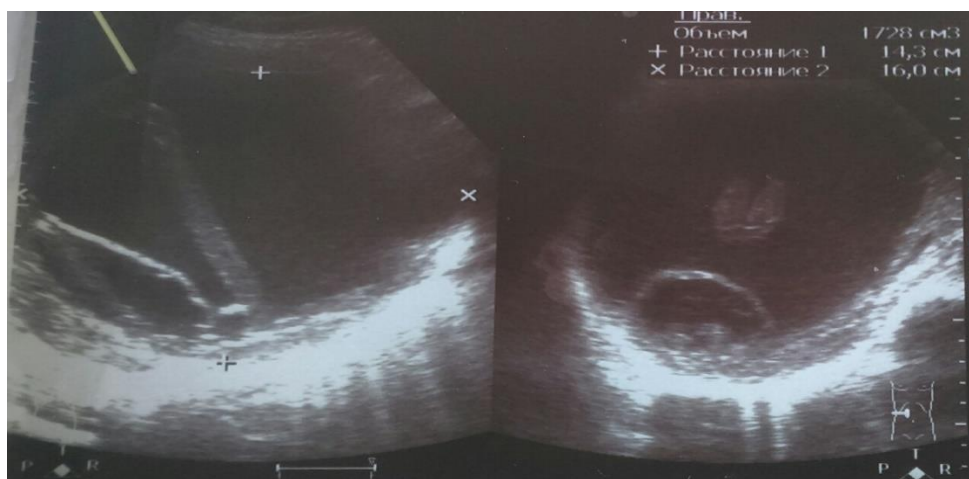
Ultrasonography showing a giant hepatic cyst (size: 143 x 160 x 145 mm; volume: 1728 cm³). The cystic mass had well-defined round shape with sharply defined outer borders and posterior acoustic enhancement. Cyst contained the characteristic "daughter" cysts, intracavitary hyperechogenic linear septa formation.
